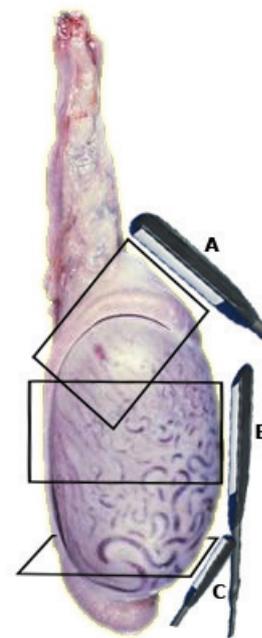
Ultrasonographic examination of the ram testicle with the use of linear probe for oblique (A), longitudinal (B) and transversal (C) scans
